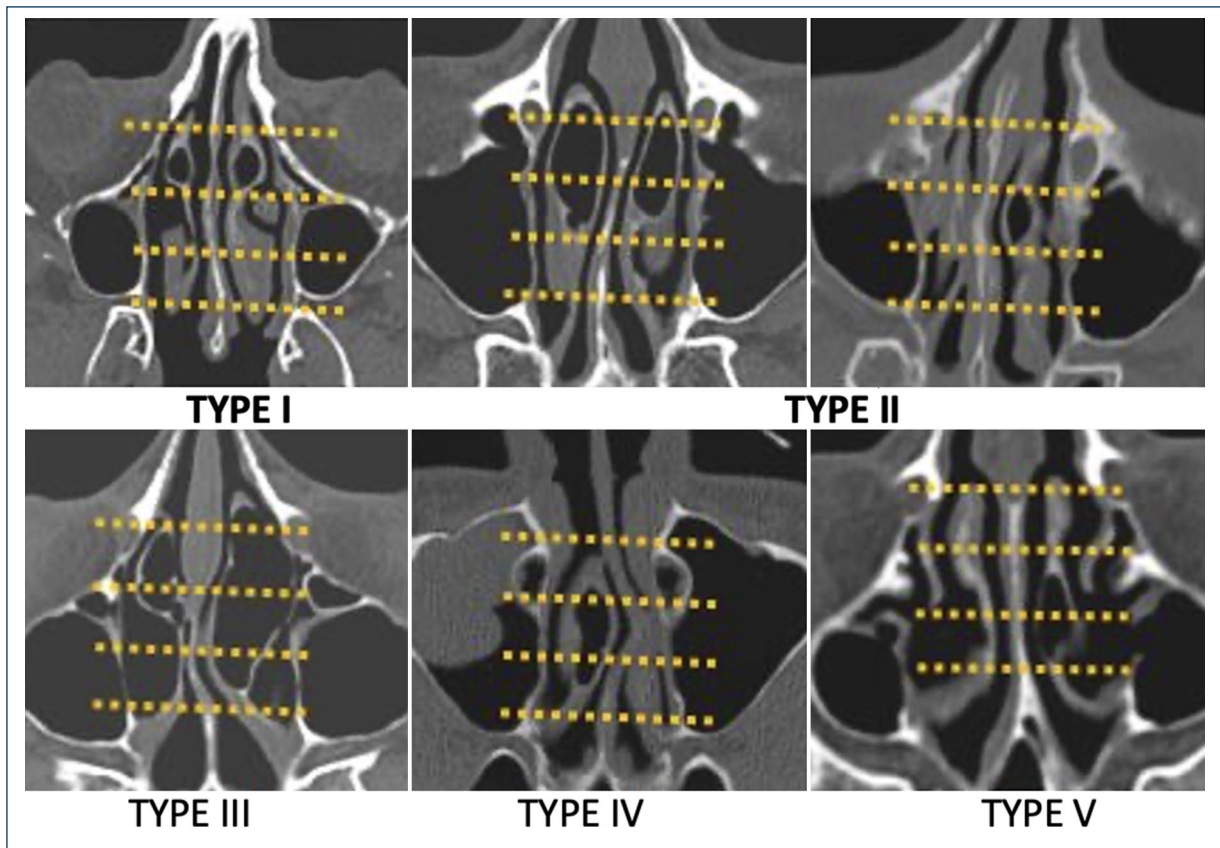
Axial CT scan images showing the types of CB according to the classification by extent of pneumatization in the anteroposterior direction within the nasal cavities (Calvo-Henriquez). Type I in the anterior third of the turbinate, type II in two anterior thirds or in the middle third, type III complete anteroposterior, type IV two posterior thirds and type V in the posterior third.
